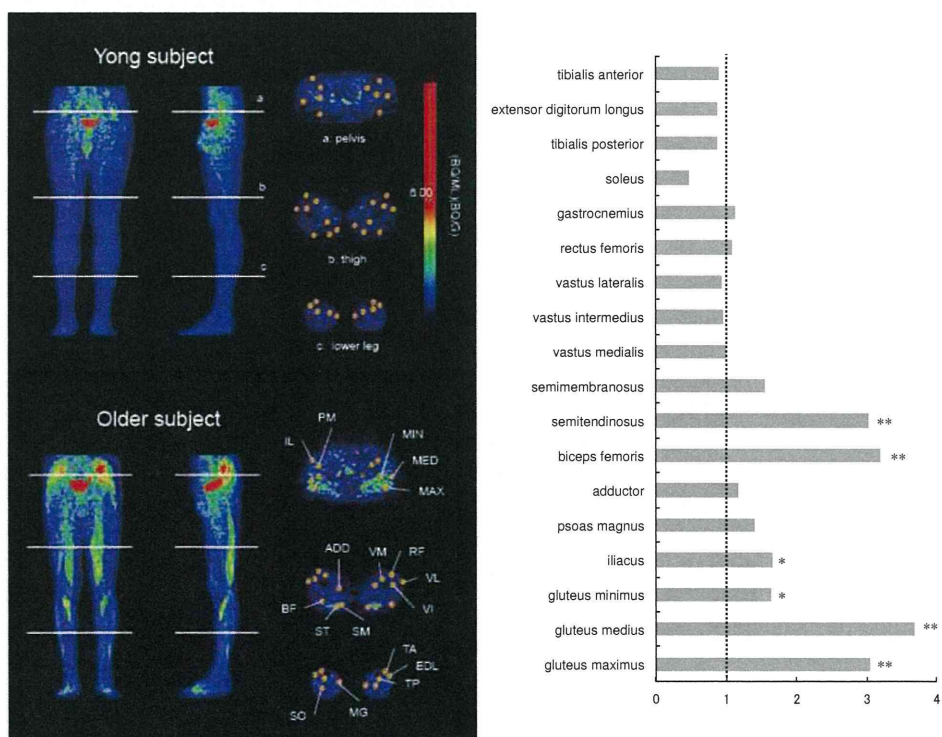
FDG PET images taken after walking in a young and older subject.
